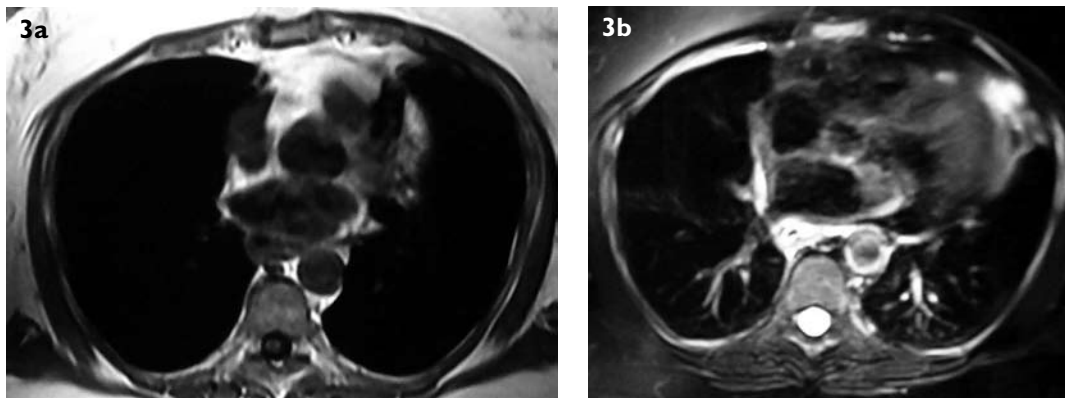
MR imaging done seven days following CT. (a) Axial T1-W and (b) T2-W images taken at the level of the left atrium show a near-complete resolution of the oesophageal wall thickening.
